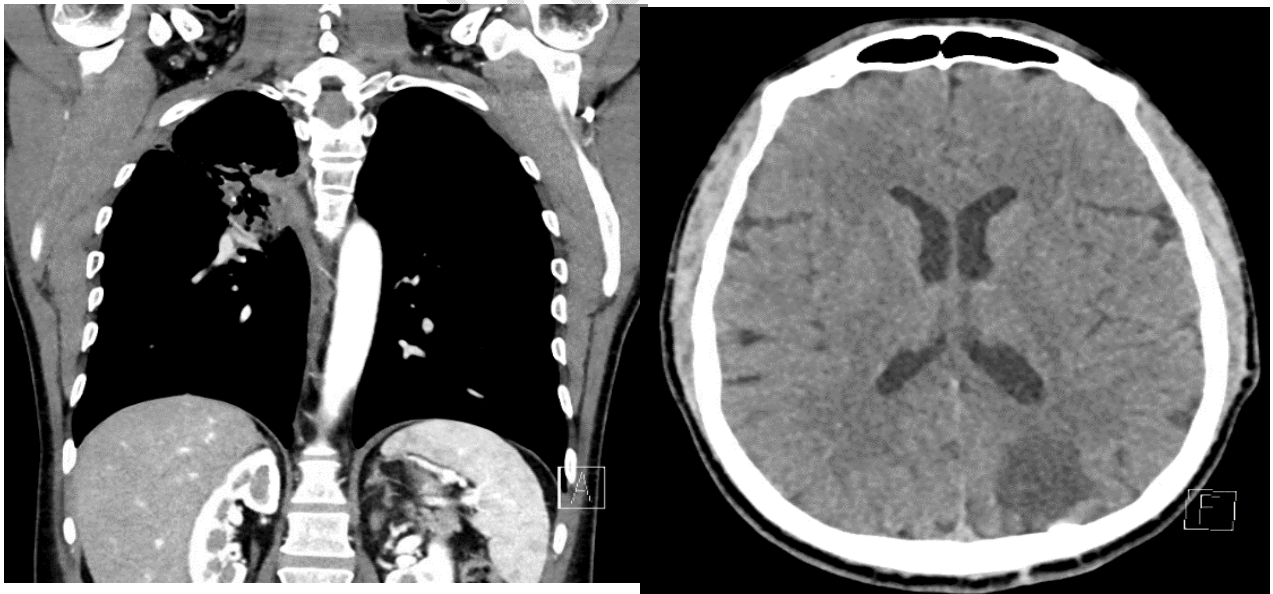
CT scan of the head and body conducted in 2021
